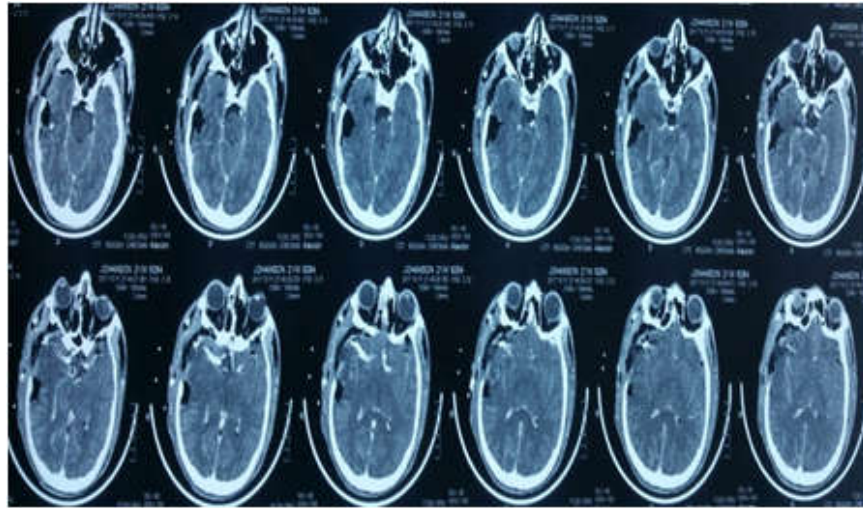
(c): Post operative CT showing total occlusion of Pial Arteriovenous fistula.
